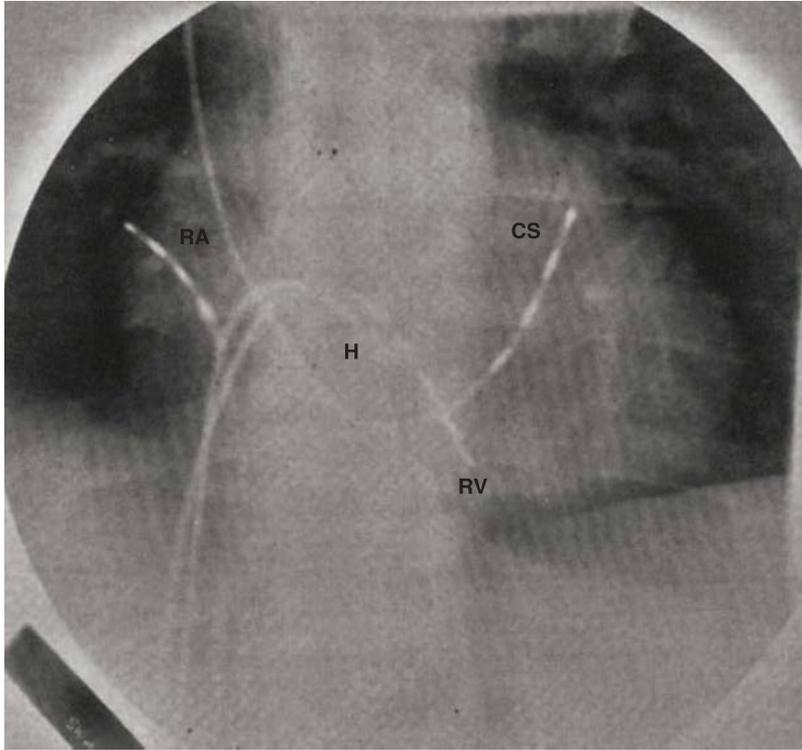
• Radiograph of endocardial catheter placement. (Key: RA = right atrium; CS = coronary sinus; RV = right ventricle; H = His bundle area.)
